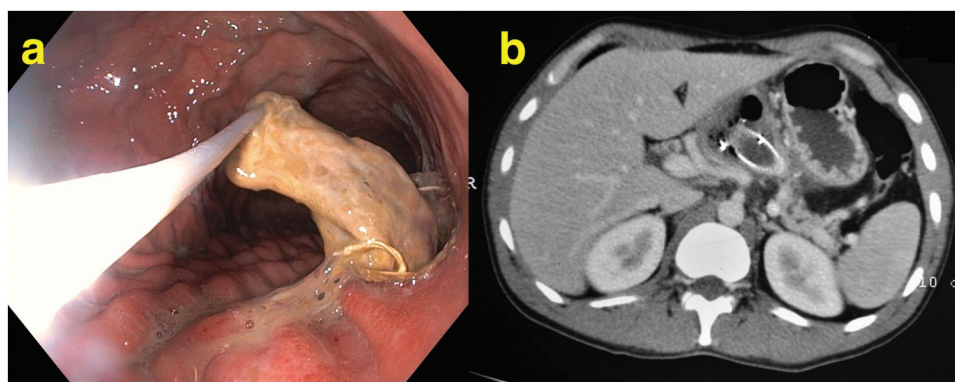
EUS guided drainage: a) direct endoscopic necrosectomy carried out; b) computed tomography imaging post-drainage.
